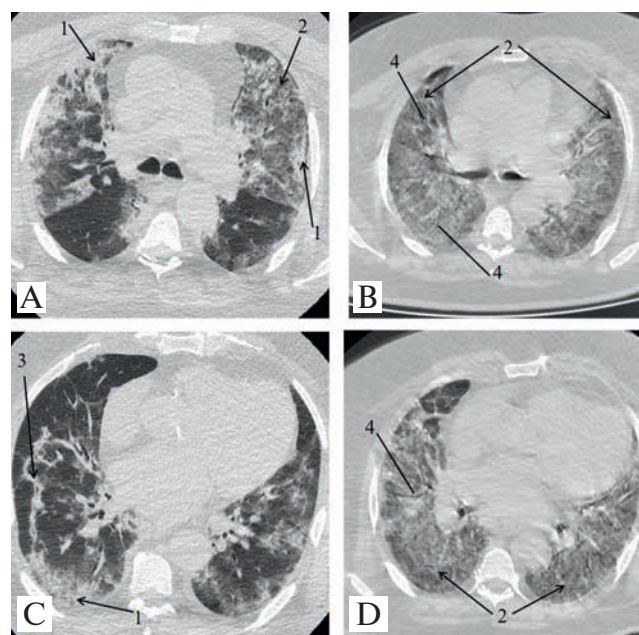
Patient S. 67 years old. Severe COVID-19 complicated by ARDS on the 20th day of the disease. Computed tomography, axial slices, 14th (A, B) and 20th (C, D) days of the disease; A, B, bilateral consolidation (1) and ground glass (2) foci and linear consolidation parallel to pleura (3); total lung involvement is more than 50%; C, D, total bilateral ground glass (2) spread with air bronchogram (4); damaged pulmonary area reaches 100%
